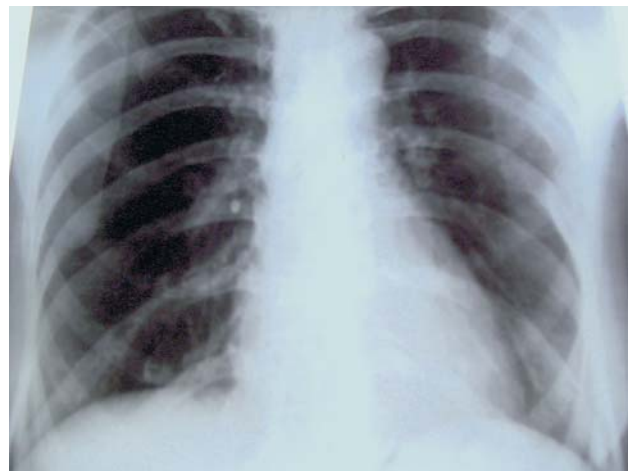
X-ray chest showing evidence of osseous destruction of the left 7th rib in its lateral aspect with associated soft-tissue swelling over the chest wall.
